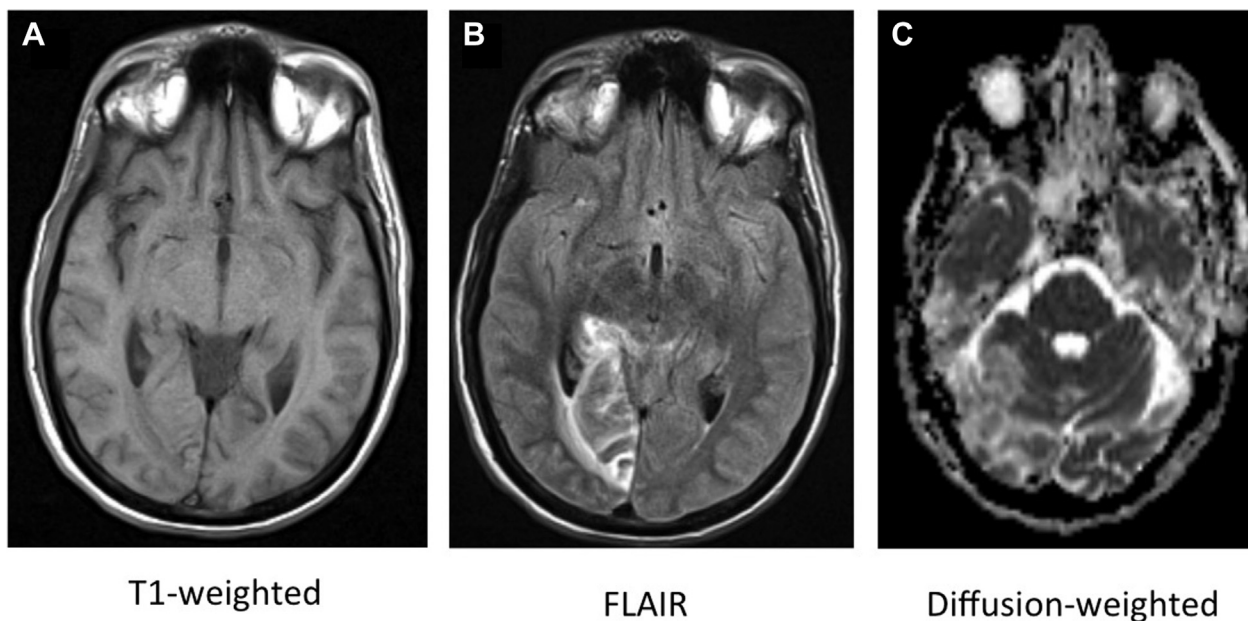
A-C, Acute right posterior inferior cerebellar artery stroke. At day 29 of his inpatient stay, the patient presented with altered mental status and was diagnosed with an acute ischemic stroke that involved the right posterior inferior cerebellar artery distribution. A, Axial T1-weighted imaging shows no evidence of hemorrhage. B, Axial fluid-attenuated inversion recovery reveals high signal on this T2-weighted sequence in keeping with edema in the right cerebellum. C, Diffusion-weighted imaging shows restricted diffusion in the region of the right cerebellum. FLAIR = fluid-attenuated inversion recovery.
